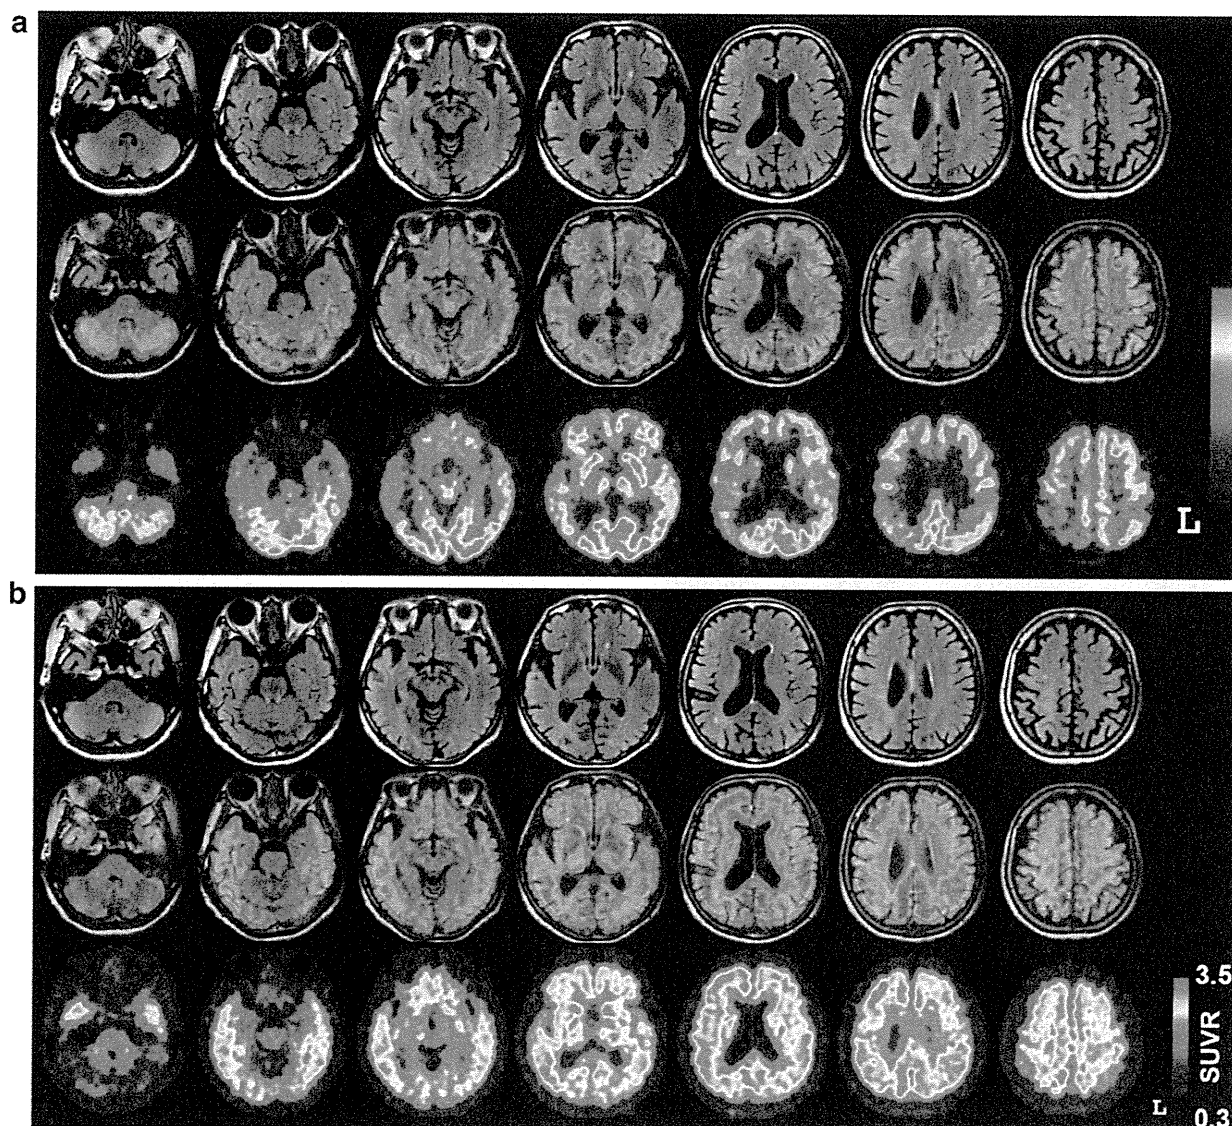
FDG-PET and PiB-PET images superimposed on the patient's FLAIR images. a MRI FLAIR axial images in November 2010 (*upper*), FDG-PET images in October 2011 (*lower*), and PET images superimposed on the patient's FLAIR images (*middle*). FDG-PET revealed diffuse cortical hypometabolism other than in the left occipital lobe, and it was more pronounced on the right. b MRI
